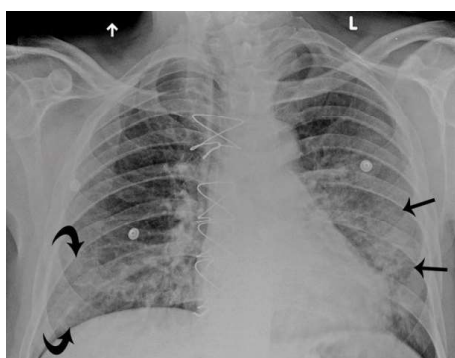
Frontal chest radiograph of a 60-year-old man with a 10-day history of fever and fatigue, obtained 10 days after symptom onset. There are subtle bilateral peripheral heterogeneous opacities (arrows) without full consolidation. There are no pleural effusions
